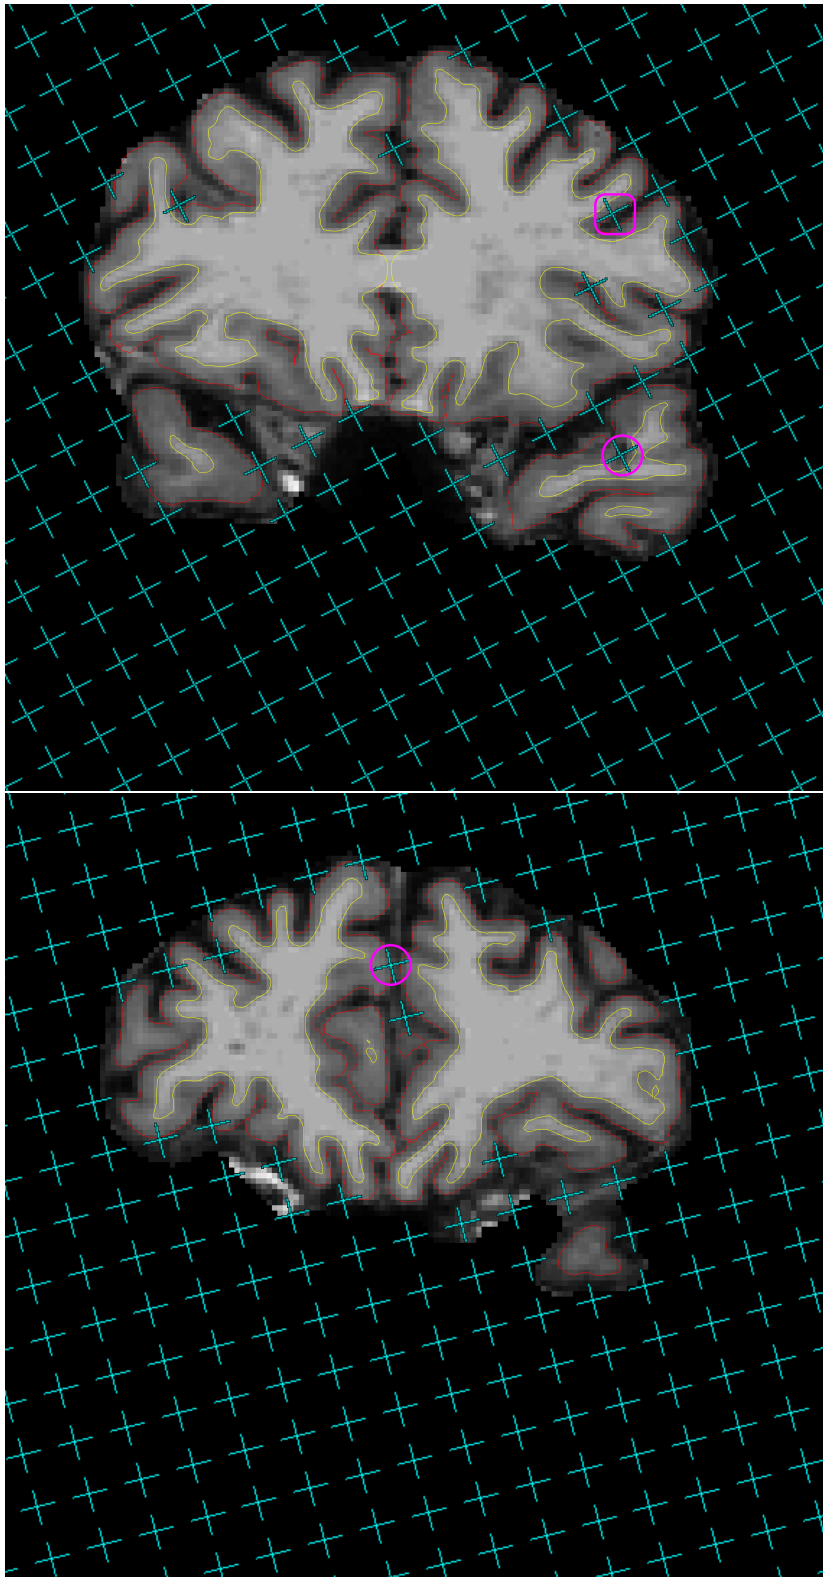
On the 13th and 14th slices of one brain MR image in the coronal view, uncounted test points (cyan) which miss the cerebral parenchyma or hit the ventricles are overlaid onto pial profiles (red lines) segmented by FREESURFER. Circles (pink) mark the uncounted test points which fall inside the grey matter boundaries (red lines) and rounded rectangles (pink, racetrack-like) mark the test points hitting exactly on the grey matter boundaries.
